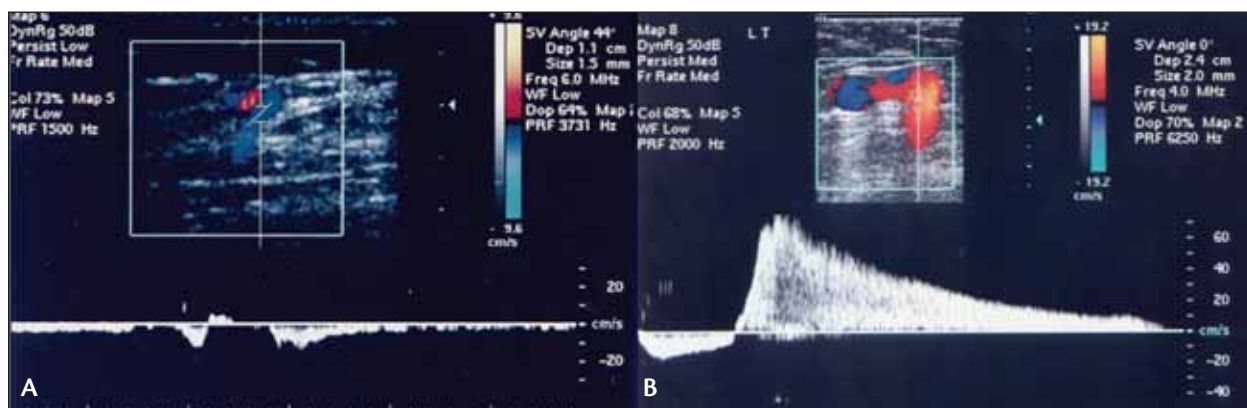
Evaluation of reflux in a perforator vein using duplex ultrasound. The patient is assessed in the standing position, and augmentation is performed distal to the perforator vein. A normal perforator vein at the medial aspect of the calf (A). During compression, inward flow is enhanced while at the release of compression, a short duration of outward flow is seen followed by prolonged inward flow. A large incompetent perforator vein at the medial aspect of the thigh (B). At the release of the compression, high-velocity, prolonged outward flow is detected. Reflux is also seen in the superficial vein connecting to the perforator.
